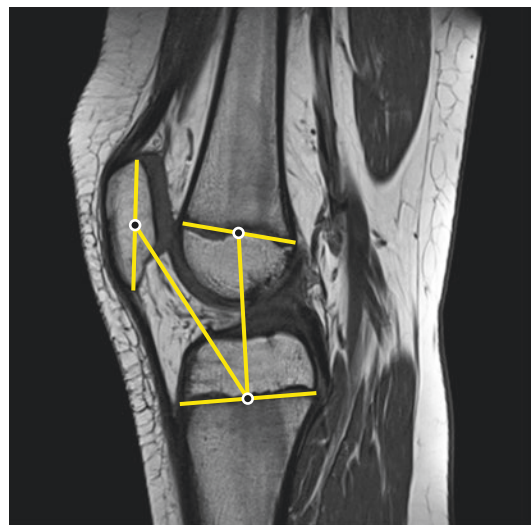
Koshino-Sugimoto ratio measured on sagittal MR image
